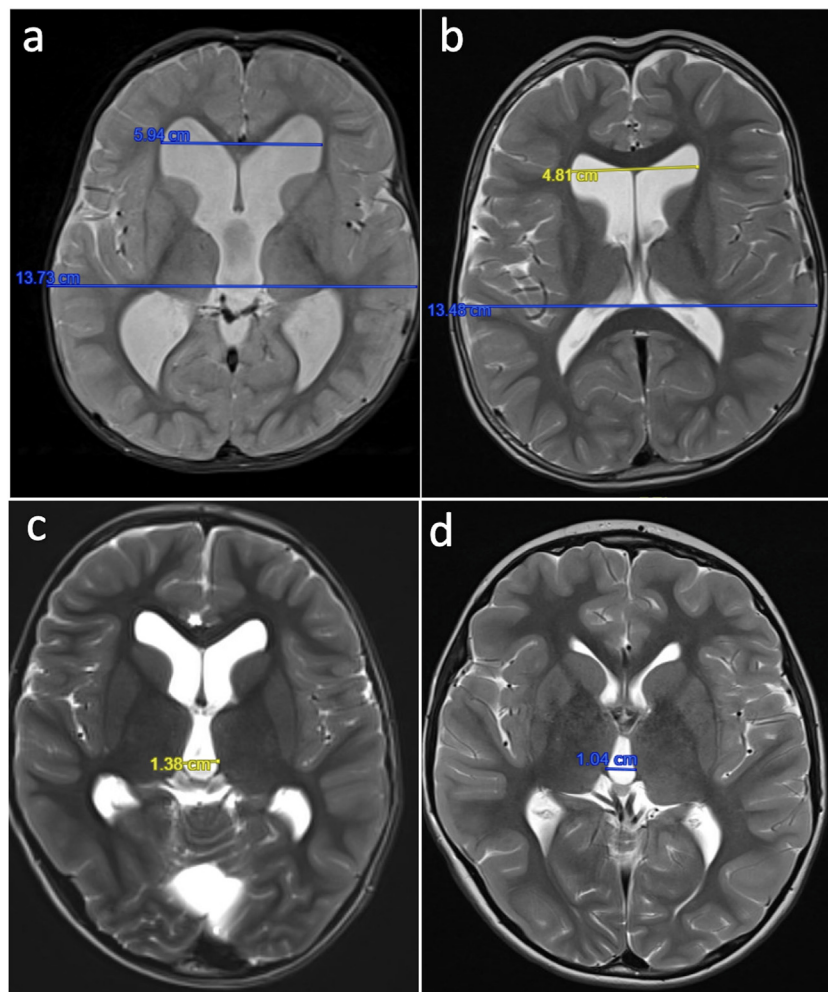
Magnetic Resonance Image (MRI) shows the ventricular system change after surgery. a) Preoperative axial T2 sequence MRI showing ventricle measurements for Evan's index. b) Postoperative axial T2 sequence MRI showing ventricle measurements for Evan's index. c) Preoperative axial T2 sequence MRI showing III ventricle measurement. d) Postoperative axial T2 sequence MRI showing III ventricle measurement.
